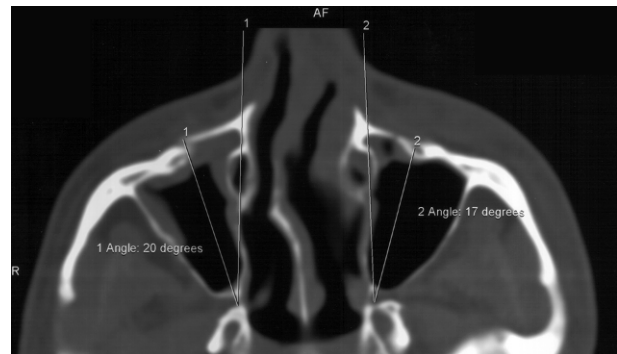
CT evaluation of the transantral approach angle of the PPF.
